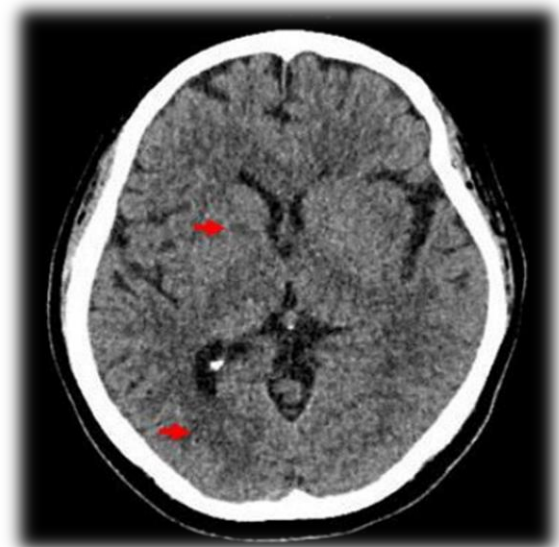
Head CT scan without contrast showed multiple lacunar infarctions in the right basal ganglia and periventricular
